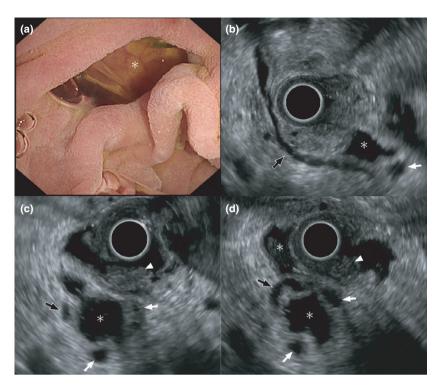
(a) Endoscopic image of the duodenum and periampullary diverticula (asterisk) after filling with viscous gel. (b) Endoscopic ultrasound (EUS) image of the pancreatic duct (arrow) and longitudinal view of the bile duct (black arrow) running behind the diverticula filled with the gel. (c, d) With the gel-filled diverticula, the pancreatobiliary ducts are delineated without interference by air. The papilla (arrowhead) was also gains better acoustic coupling without being compressed by the EUS probe.
